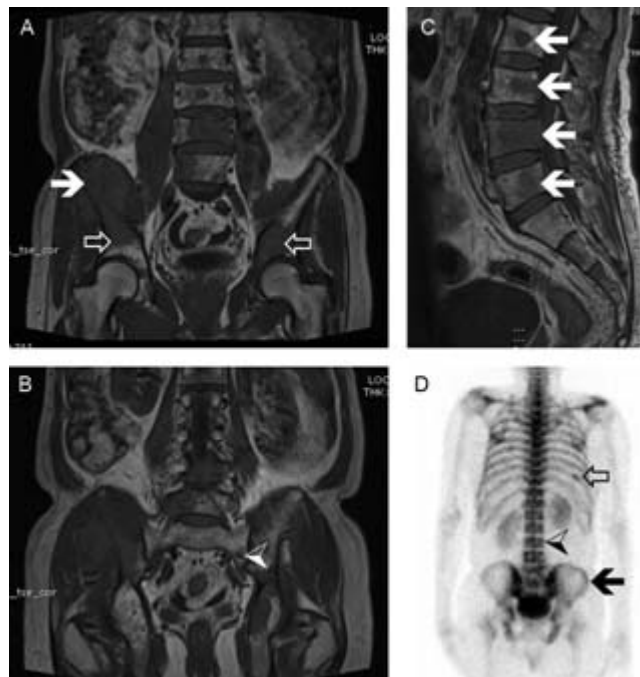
(A,B) Coronal T1 weighted images show positive lesions at right iliac bone (white arrow), bilateral acetabuli (open arrow) and left sacral ala (arrow head). (C) Sagittal spine T1 weighted image shows positive lesions at L2 – L5 vertebral bodies (white arrows). (D) Bone scintigraphy shows faintly increased tracer uptake, probably positive lesion at right iliac bone (black arrow) and a probably negative lesion at posterior right 9th rib (open arrow), while lumbar spine appears to have slightly decreased tracer uptake (arrow head) and is interpreted as negative.
